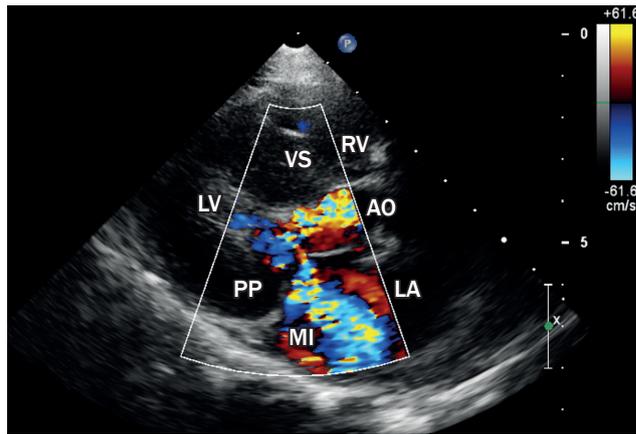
Parasternal long-axis view, showing obstruction to flow in the left ventricular outflow tract and mitral regurgitation. VS: interventricular septum; PP: posterior wall; LV: left ventricle; AO: aorta; LA: left atrium; RV: right ventricle; MI: mitral insufficiency.
